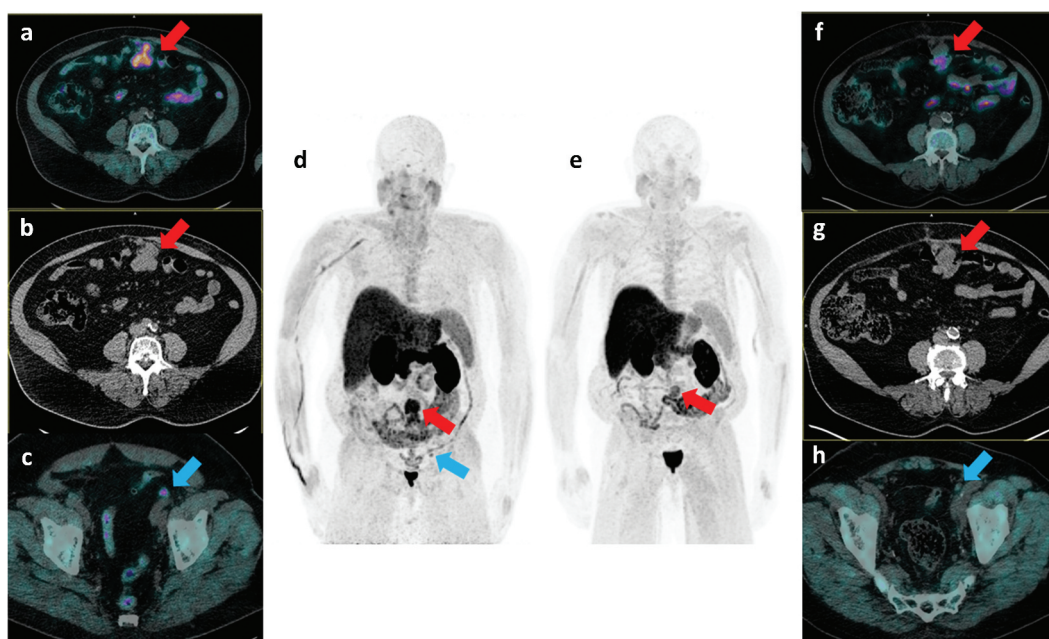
A 72-year old mCRPC patient (ISUP grade 4) treated with Olaparib + abiraterone after progression to Docetaxel. Baseline $^{[18\text{F}]}\text{F}$ -choline PET/CT (A-D: transaxial fused, CT, transaxial fused and MIP images respectively), showed a large peritoneal mass with an intense radiotracer uptake (PCa localization confirmed with laparoscopic biopsy – red arrow) and an area of focal uptake corresponding to a left external iliac lymph node (blue arrow). PSA was 41 ng/ml. The patient performed a second $^{[18\text{F}]}\text{F}$ -choline PET/CT (E-H: MIP, transaxial fused, CT and transaxial fused images respectively) 3 months after starting PARPi therapy. The exam showed an evident reduction of the uptake intensity and of the size of the peritoneal mass (red arrow) and the complete normalization of the pathological uptake in correspondence of the left external iliac lymph node metastasis (blue arrow). A standardized tool to assess response to oncological treatments in PCa is still an unmet clinical need. $^{[18\text{F}]}\text{F}$ -choline and PSMA-ligands PET/CT are often used in daily clinical practice, although they are still not included in most updated guidelines for therapy response assessment, mainly due to the low quality of scientific evidence on support. Therefore, $^{[18\text{F}]}\text{F}$ -FTT PET could have a rising relevance for this indication if validated by prospective trials.
